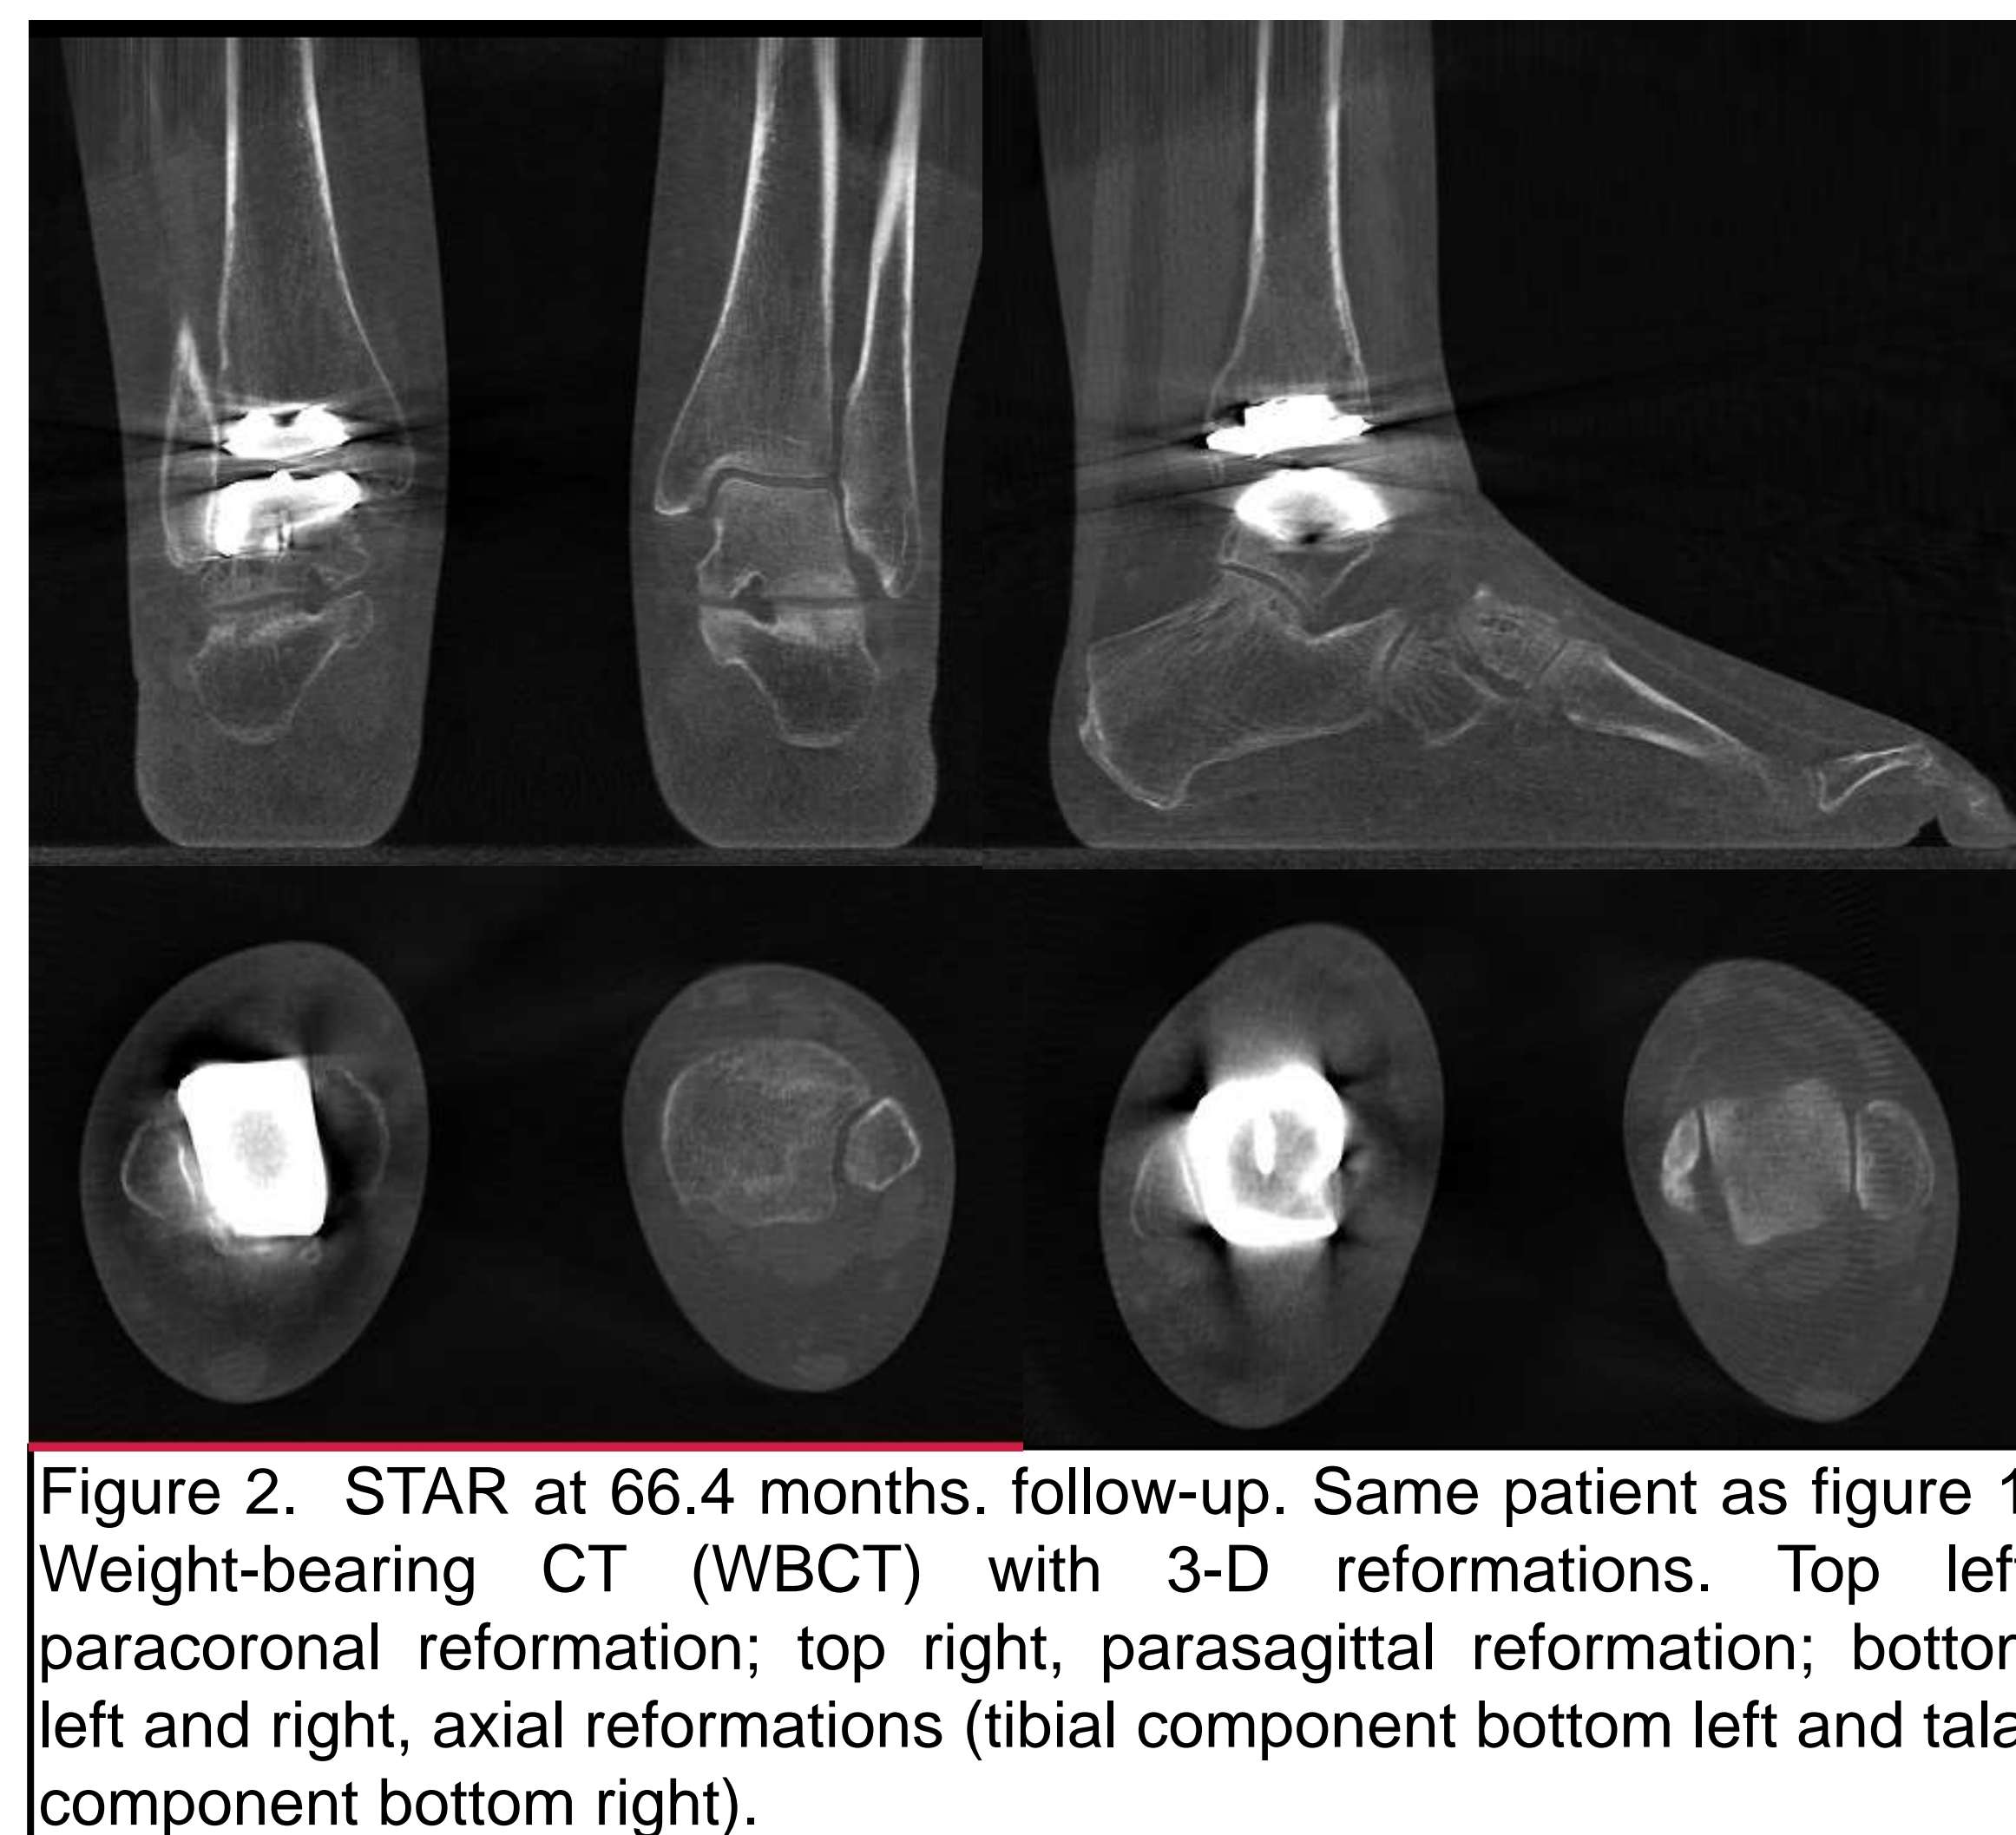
STAR at 66.4 months. follow-up. Same patient as figure 1. Weight-bearing CT (WBCT) with 3-D reformations. Top left, paracoronal reformation; top right, parasagittal reformation; bottom left and right, axial reformations (tibial component bottom left and talar component bottom right).
